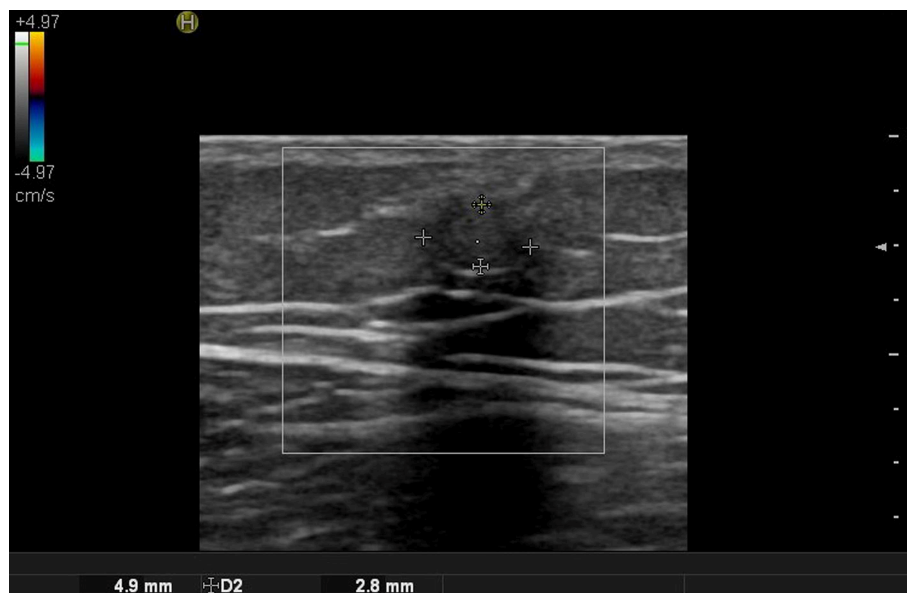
Ultrasound image of pilomatricoma.
